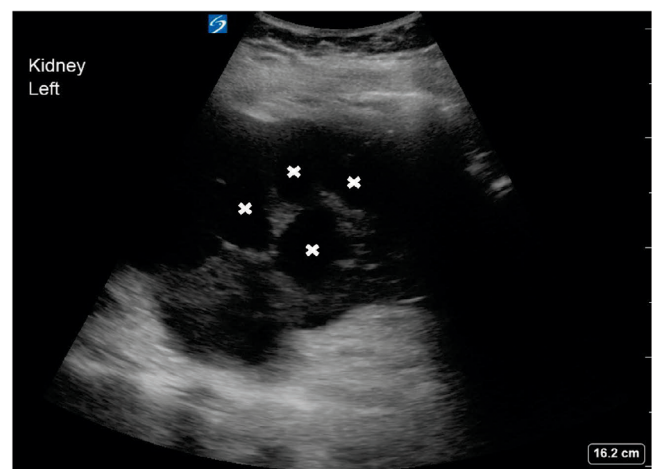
Ultrasound of the left kidney demonstrating multiple fluid filled locules (white x's) in the classic “bear paw” pattern.
